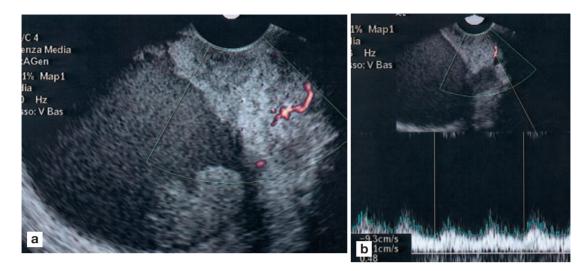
Transvaginal color Doppler of large mucinous ovarian carcinoma. a The lesion has a mixed structure, with both solid and liquid components. Color flow signals with tortuous course are seen in the solid portions. b Spectral analysis reveals low-impedance flow pattern
